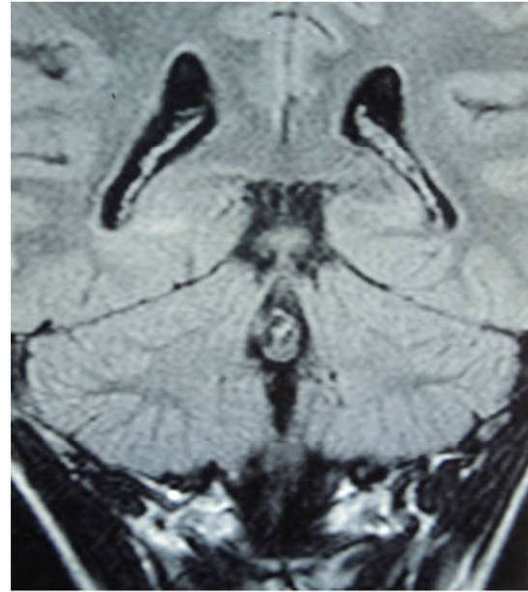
A repeat magnetic resonance imaging scan (done after 15 days of the first scan), which does not show change in the position of the cyst or increase in the size of the ventricles.
